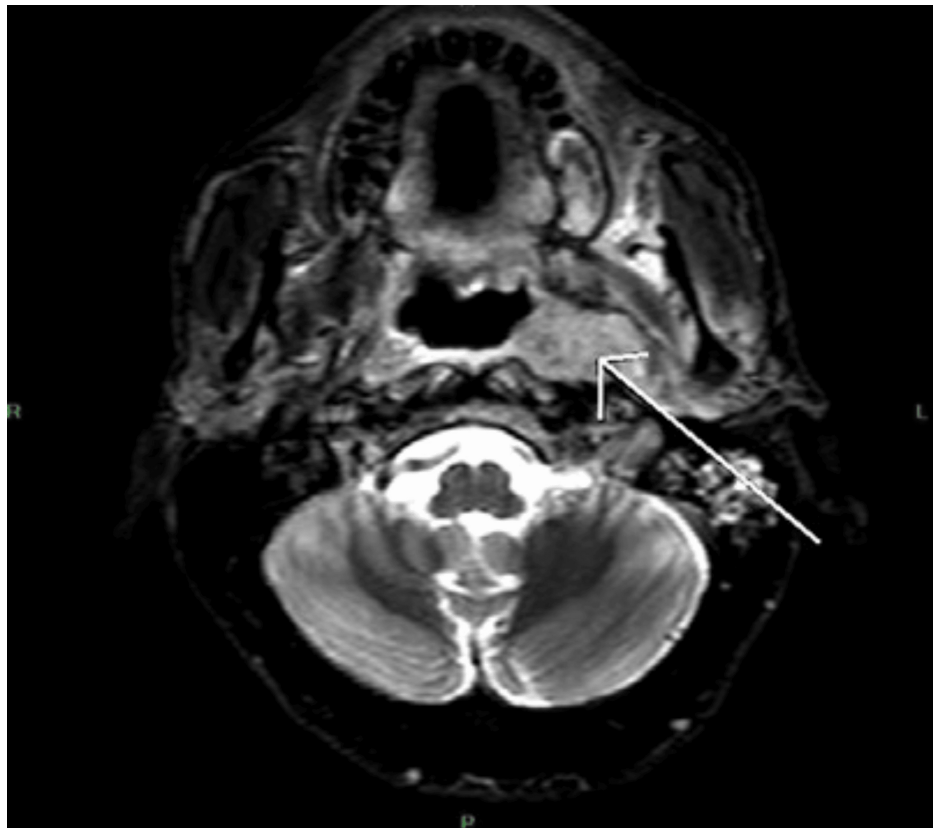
Magnetic resonance imaging (MRI) of the skull, short tau inversion recovery (STIR) sequence.
